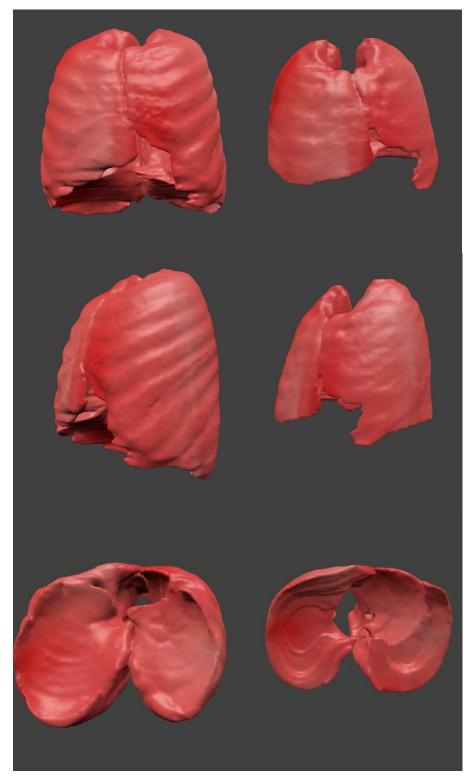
Snapshot of rendered 3-dimensional images of lung tissue from CT scans taken during tidal breathing (on right) and following maximal glossopharyngeal insufflation (on left) from the same competitive freediver [coronal, sagittal and inferior views]. *Images are scaled for direct volume comparison.*
